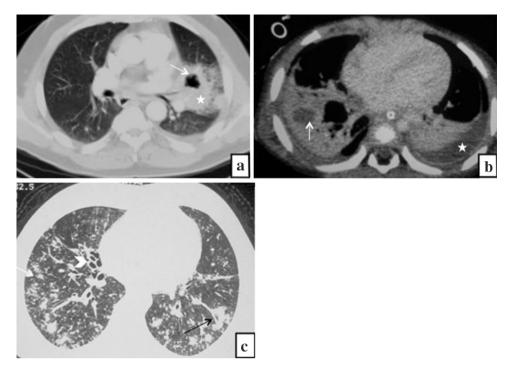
a Chest CT in a patient with *E. coli* pneumonia. Patchy area of consolidation (*asterisk*) is seen in left upper lobe with cavitation (*white arrow*) and adjacent GGOs. b Chest CT in another patient with *E. coli* pneumonia. Bilateral lower lobe consolidation with abscess formation in right lower lobe (*white arrow*). Note pleural enhancement and thickening on both sides with left empyema (*asterisk*). c Chest CT shows the presence of nodules in both lungs (*white arrow*) with patchy areas of consolidation (*black arrow*) in a patient with hemophilus pneumonia. Note made of bronchiectasis involving right middle lobe (*arrow head*)
